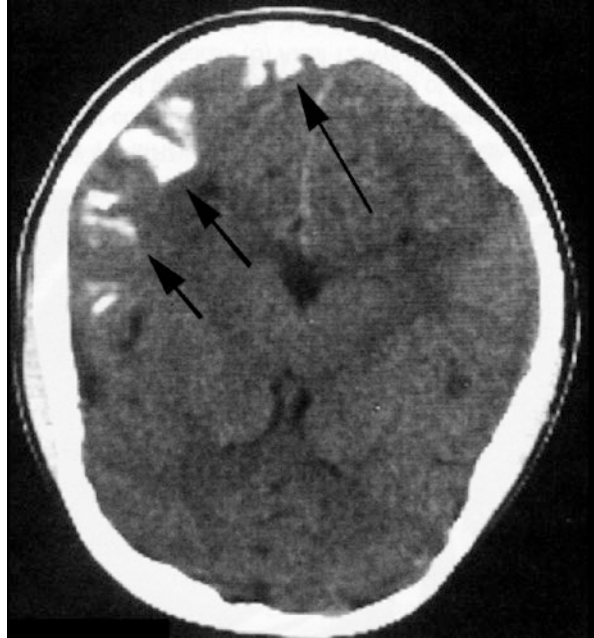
Axial CT image of a young woman with Sturge-Weber shows coarse cortical calcifications (arrow)
